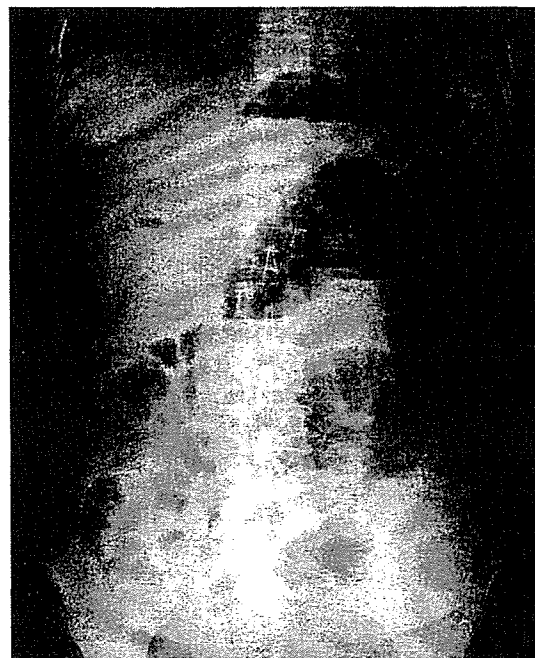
X-ray film of the abdomen showed niveau of the small intestine, the so-called herring-bone sign
